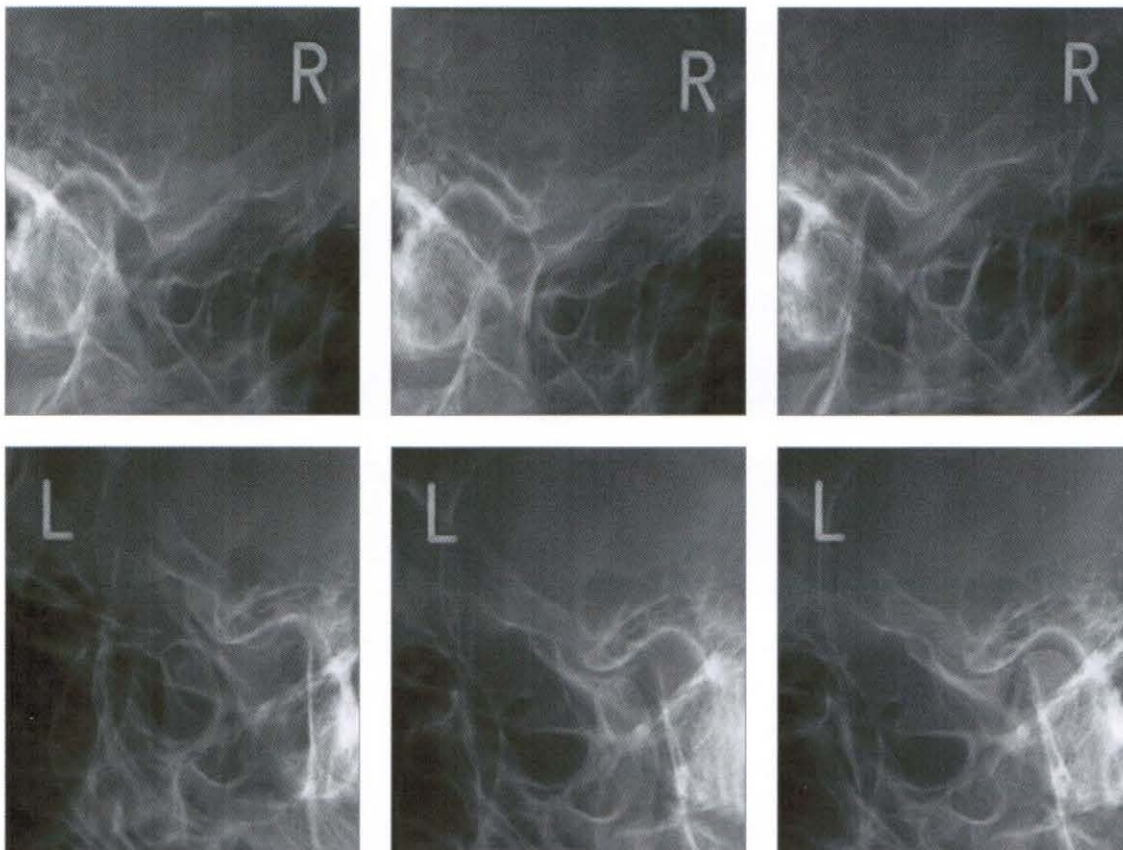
Postsurgical transcranial radiograph
